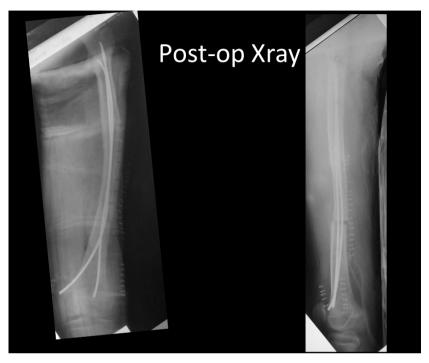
Failure to achieve a 3 point fixation seen at post op radiograph.
